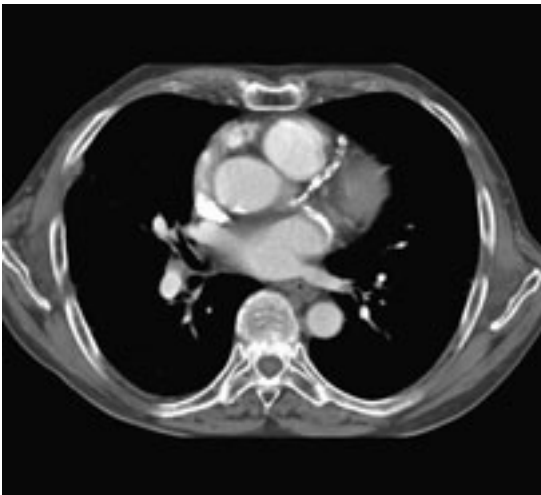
Multi-detector CT. Diffuse sclerosis of the LCA.
